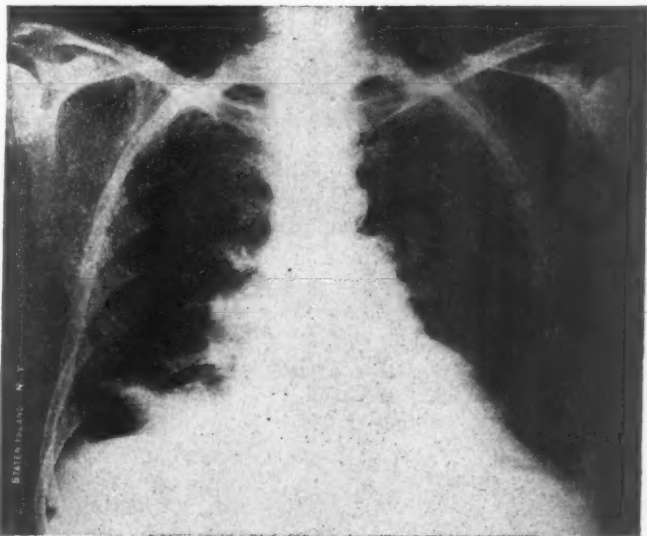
Case 3. Roentgenogram showing marked enlargement of the heart. Note absence of pulmonary congestion. There are small infarcts at the right lung base.
